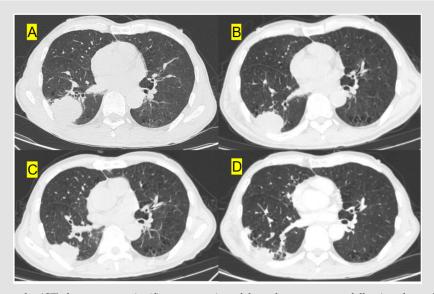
Computed Tomography (CT) demonstrates significant regression of the pulmonary tumor following chemotherapy.
